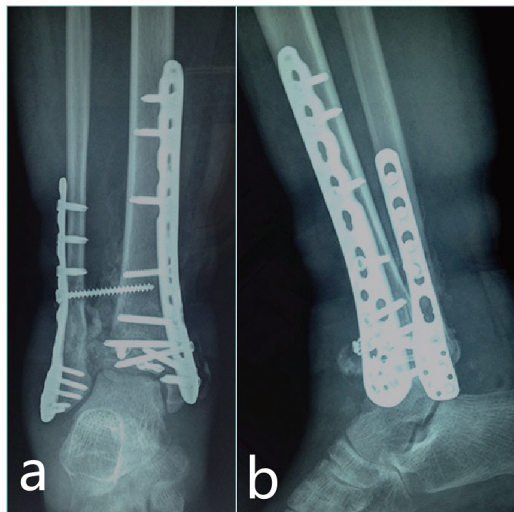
Radiographs taken 3 months after ORIF (open reduction and internal fixation) showing separation of the inferior tibiofibular syndesmosis and subsidence of the distal tibia articular surface, accompanied by the periosteal reaction
